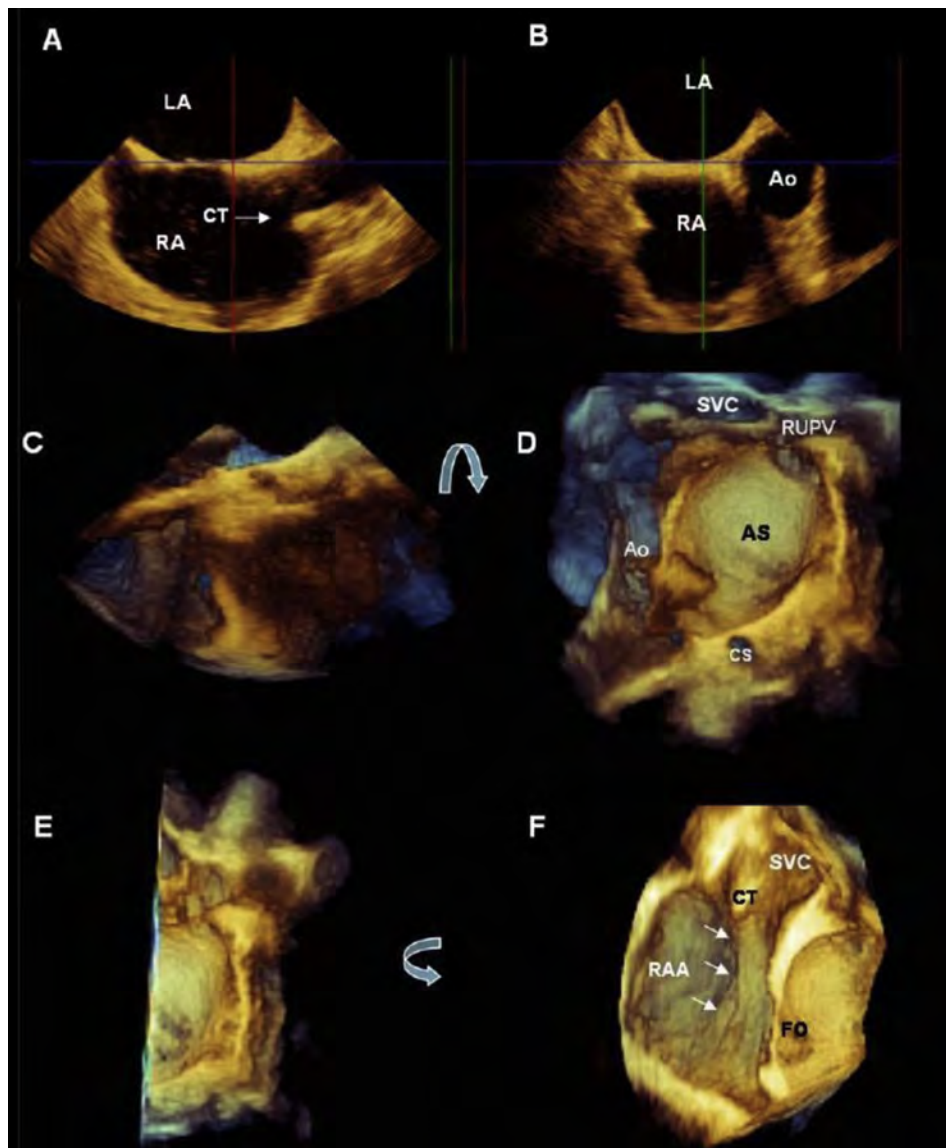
Still image depicting the two perpendicular 2D TEE planes (A and B) used to acquire a zoomed 3DE data set of the IAS (C). The left side of the atrial septum is shown in the en face perspective visualized after a 90° up–down rotation (*curved arrow*) of the data set (D). Image D can be cropped to remove the left half of the atrial septum (E) and when rotated 90° counterclockwise (*curved arrow*) (F), the entire course of the crista terminalis from the SVC toward the IVC (*arrows*) can be visualized. Ao, aorta; AS, atrial septum; CS, coronary sinus; CT, crista terminalis; FO, fossa ovalis; RAA, right atrial appendage.
